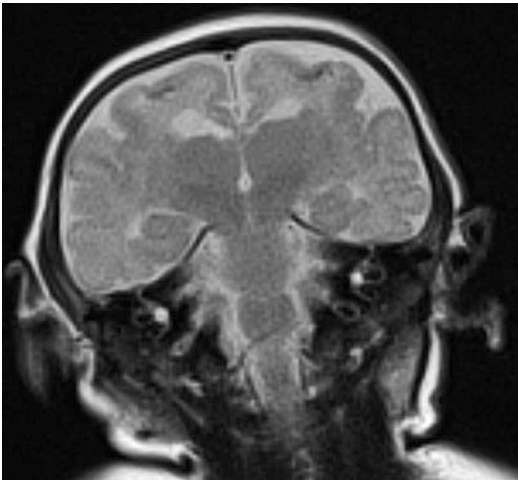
Coronal T2-weighted images through the brain demonstrating T2 dark punctate calcifications at the gray-white junction and lissencephaly in a neonate with Zika virus infection. (Image courtesy of Karin Nielsen, MD, MPH)
